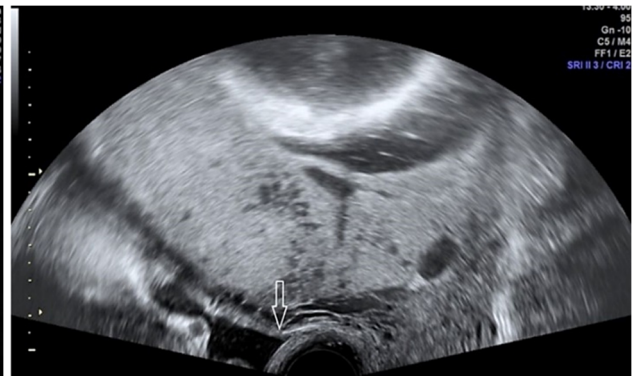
Transvaginal sonogram: thinning of utero-vesical interface (white arrow) in pregnant woman, 31 years old, 34 GW, no obstetrical history in the past; present delivery by Cesarean section; placenta praevia associated with placenta increta. GW: Gestational weeks.
